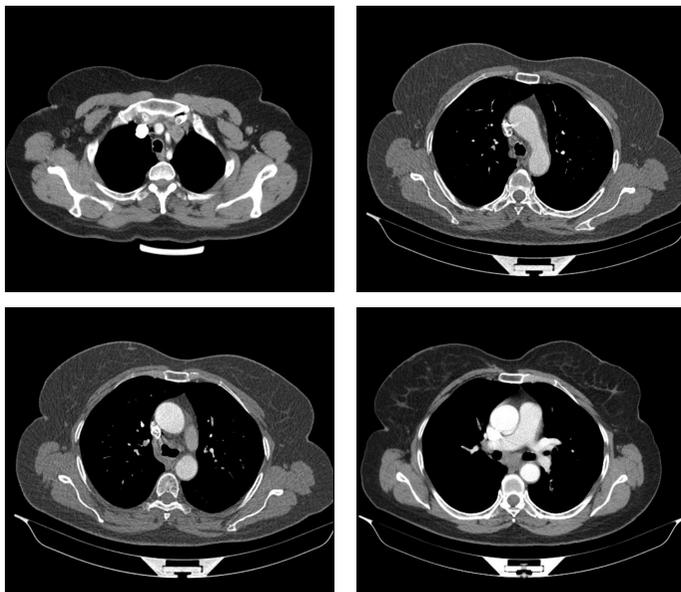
Chest CT scan showing multiple calcified nodules in the trachea and main bronchi, sparing the posterior membrane.
